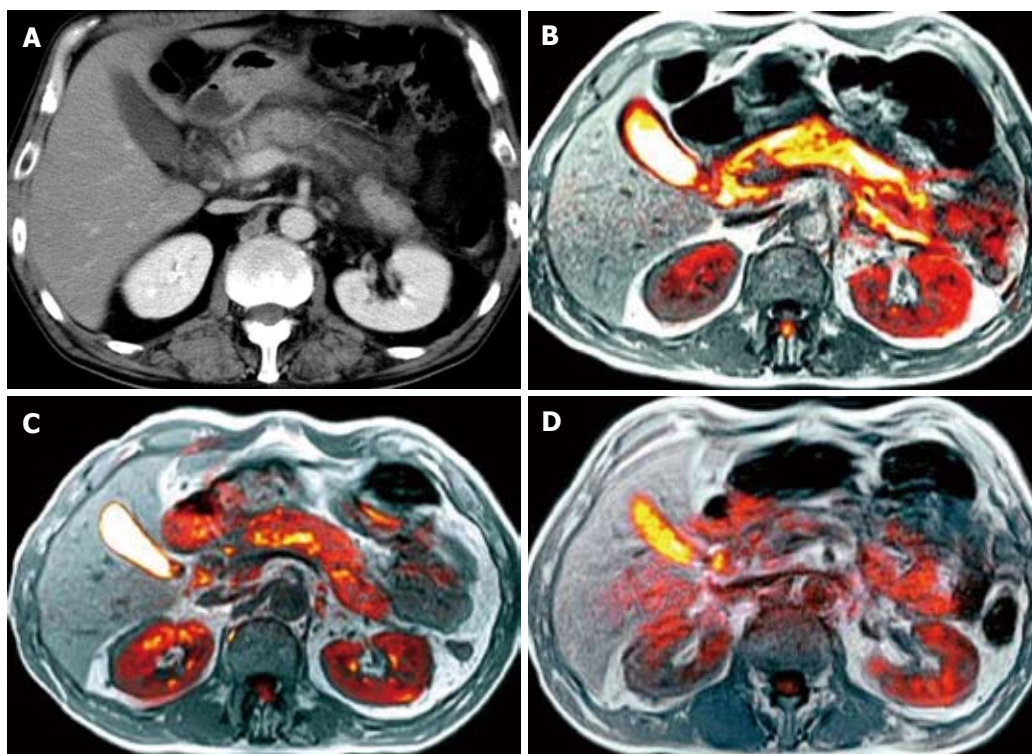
A CT scan at admission revealing enlarged pancreas complicated by acute multiple ascites (A), a fusion image at admission (B), on days 10 (C) and 50 (D) showing bright signals in the whole pancreas and ascites around it, diminished pancreatic enlargement and slightly decreased signal-intensity, as well as disappearance of all signs of acute pancreatitis, respectively.
